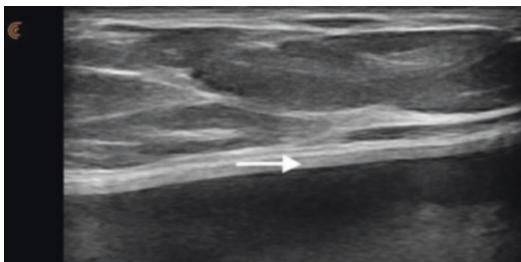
Grayscale ultrasound image of textured silicone gel breast implant. Arrow depicts the elastomer shell with fuzzy contour
